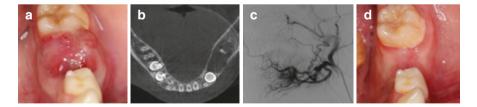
A 9-year-old boy was referred for evaluation of swelling at the left mandibular gingiva associated with progressive mobility of the first permanent molar. (a) The swelling presented a predominant erythematous color with small hemorrhagic foci distributed on a thin overlying mucosa. (b) On palpation, it was soft in consistency and easily compressible, with a prominent pulsatile component. Cone-beam tomography showed an intraosseous destructive lesion through a hypodense image in the left posterior mandible. (c) Angiography demonstrated a large, high-flow AVM. (d) Impressively, the AVM spontaneously regressed after angiography without embolization. The patient is on a 24-month follow-up with no signs of recurrence
